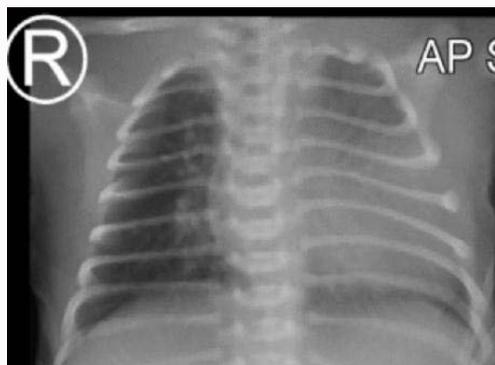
The chest X-ray.
